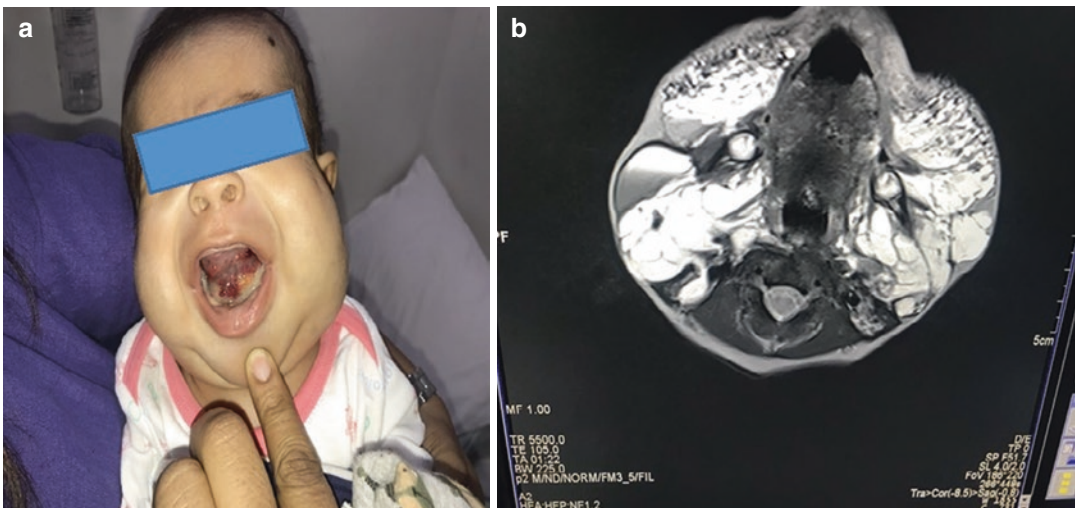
Cystic Hygroma (a: Sublingual cystic swelling; b: CT scan image) (P.S.: Image courtesy Dr Dilip Chavan; Director children anesthesia services, Mumbai;
